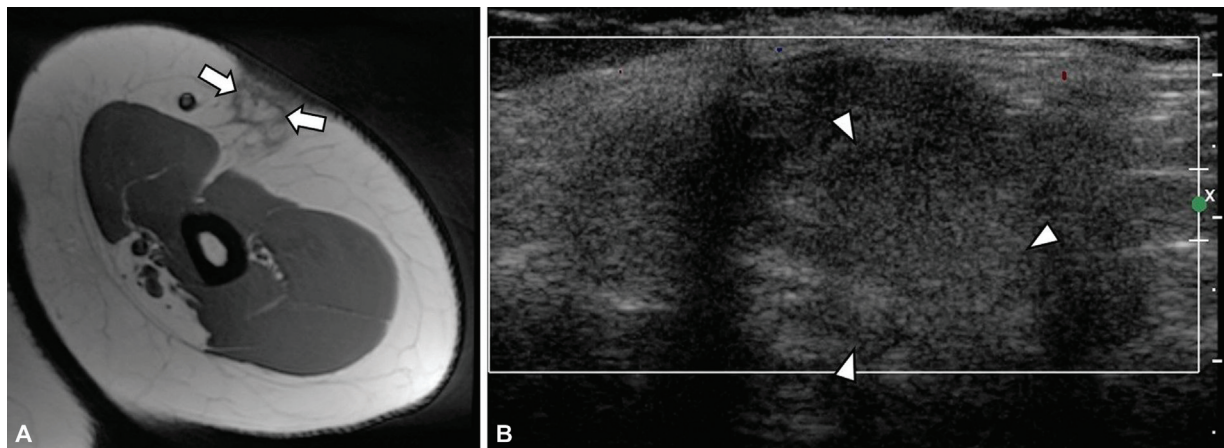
A 67-year-old woman with palpable mass and skin dimpling to the lateral arm at site of prior trauma. (A) Axial T1-weighted magnetic resonance (MR) image shows a mass (arrows) in the upper arm with intrinsic T1 hyperintensity identical to subcutaneous fat and an irregular peripheral border of low signal. (B) Doppler ultrasound (US) image shows an echogenic lesion (arrowheads) without internal vascularity compatible with fat necrosis.
